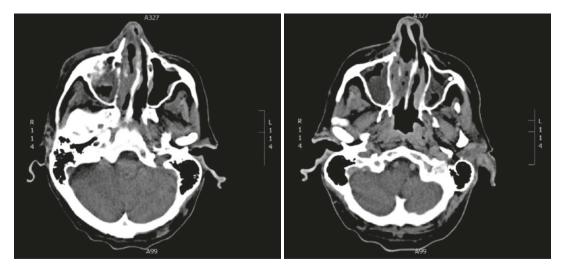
CT scan of the paranasal sinuses
